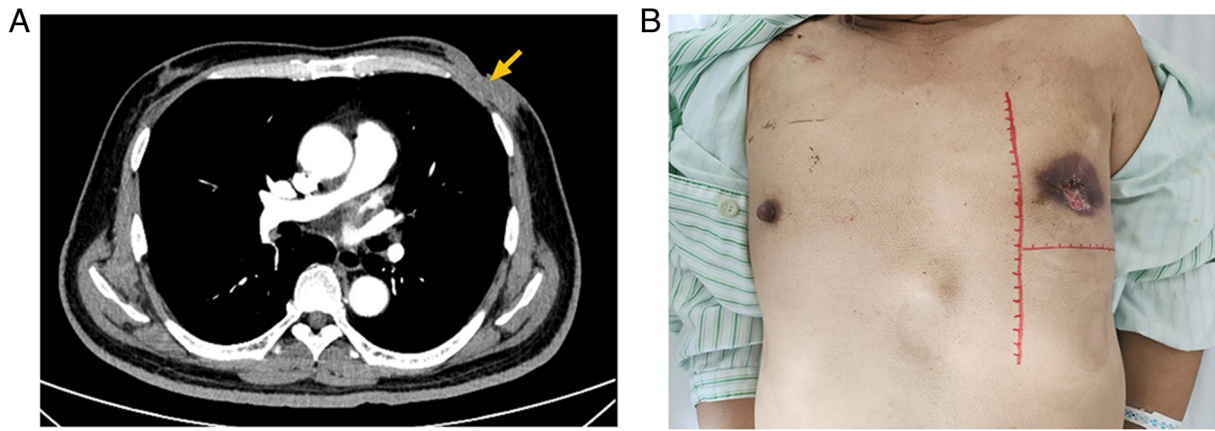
Post-chemotherapy images in October 2023 showing significant reduction of the breast tumor. (A) Computed tomography scan showing the reduced breast tumor size (yellow arrow). (B) Outward appearance of the breast tumor.
